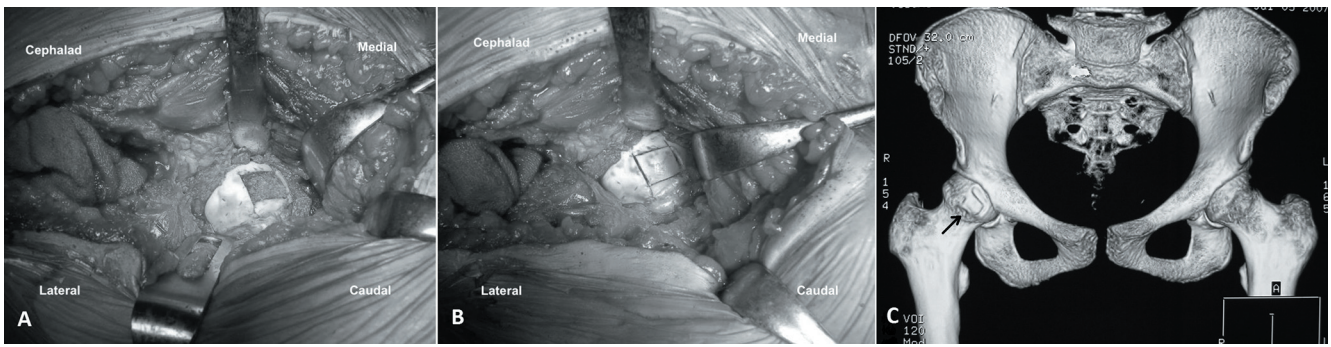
A-C. (a and b) Cancellous bone graft is placed and trapdoor segment is replaced without fixation. (c) Postoperative 3D CT image shows the trapdoor segment (black arrow) which is located at the anterior and non-weightbearing surface of the femoral head.
